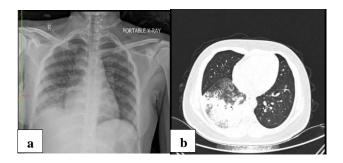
(a) X-ray chest anteroposterior view, and (b) HRCT thorax on admission.
